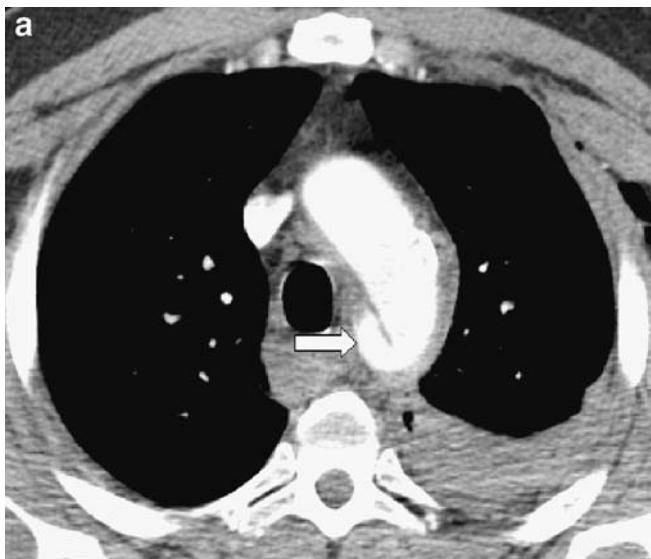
a Axial image from contrast enhanced CT scan demonstrating a focal contour bulge of the aortic arch (arrow) consistent with a pseudoaneurysm due to traumatic aortic injury. b Reformatted coronal CT image showing the traumatic aortic pseudoaneurysm (arrow) located medial to the aortic isthmus and adjacent to mediastinal hematoma. The pseudoaneurysm exhibits the characteristic mushroom-like appearance with the neck of the aneurysm resembling the stalk and the body resembling the cap of a mushroom
